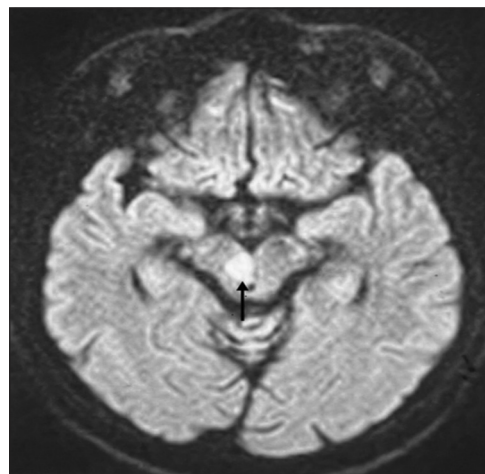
Magnetic resonance imaging brain axial diffusion-weighted image showing restricted diffusion in right ventral paramedian midbrain sparing cerebral peduncle
